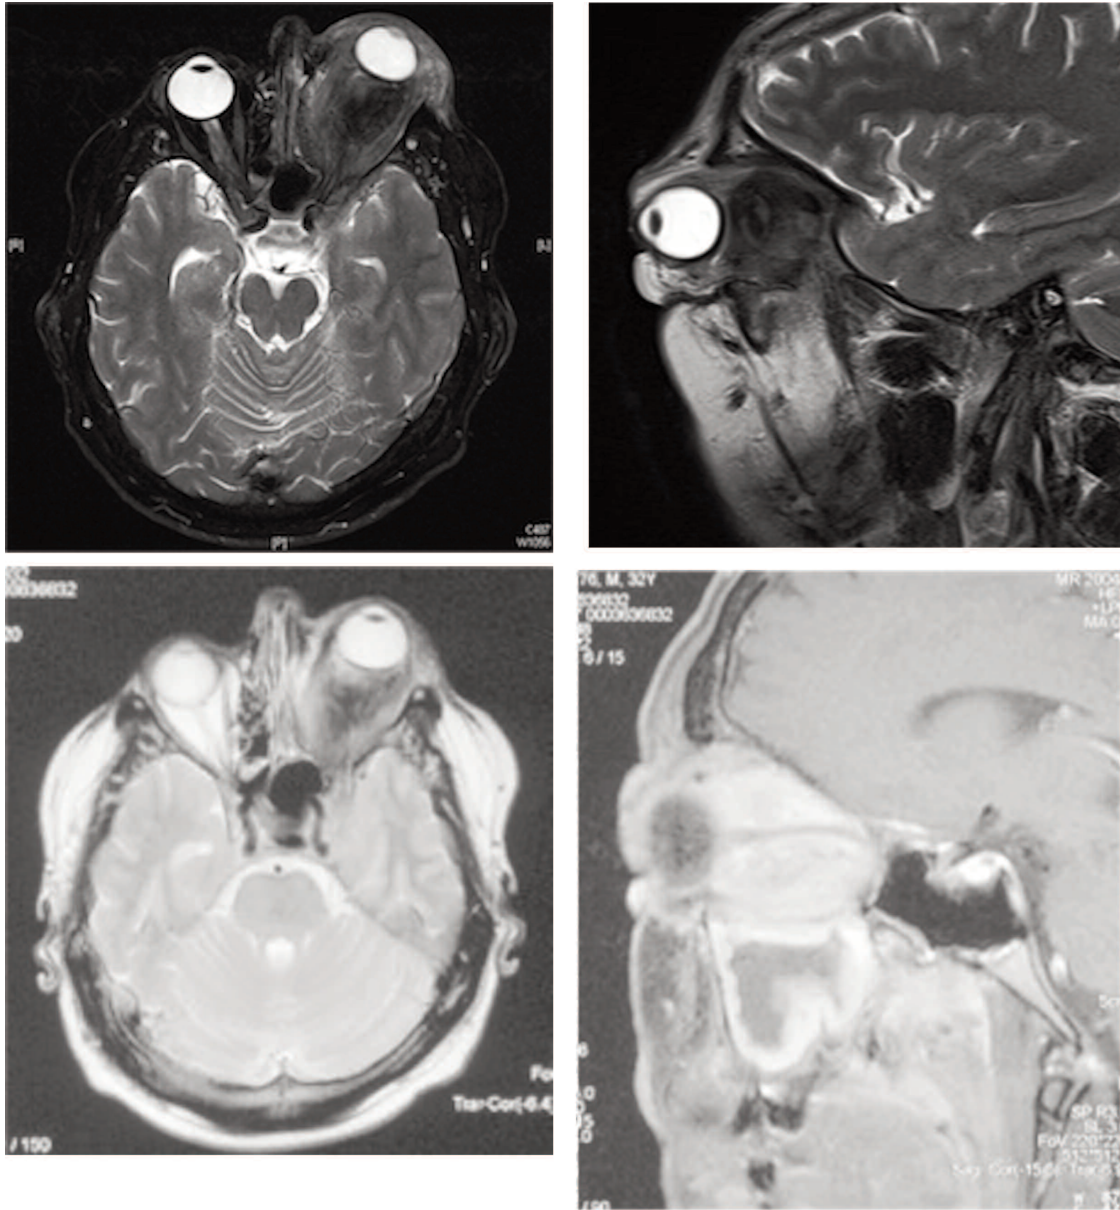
Magnetic resonance images (MRI) before and after rituximab (RTX) infusions. Axial (upper left) and sagittal (upper right) short-tau inversion recovery images before RTX treatment showing left exophthalmos and inflammatory tissue involving extraconal and periorbital fat. MRI 5 weeks after rituximab: Axial (lower left) and sagittal (lower right) T1-weighted images after gadolinium injection. There was persistence but improvement in both fatty infiltration and the left exophthalmos. The persistence of inflammatory reaction is evident inside the maxillary sinus and the cavernous sinus, in the sagittal view postcontrast injection.
